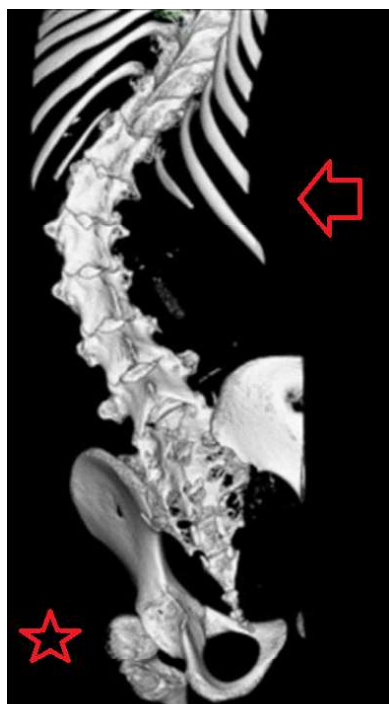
A reconstructed three-dimensional CT image of a person with spinal muscular atrophy type 1. Note the marked scoliosis (red arrow) but also the dysplasia of the hip (red star). (Courtesy of *JA Clin Rep* 6, 28 (2020). <https://doi.org/10.1186/s40981-020-00334-7>)
